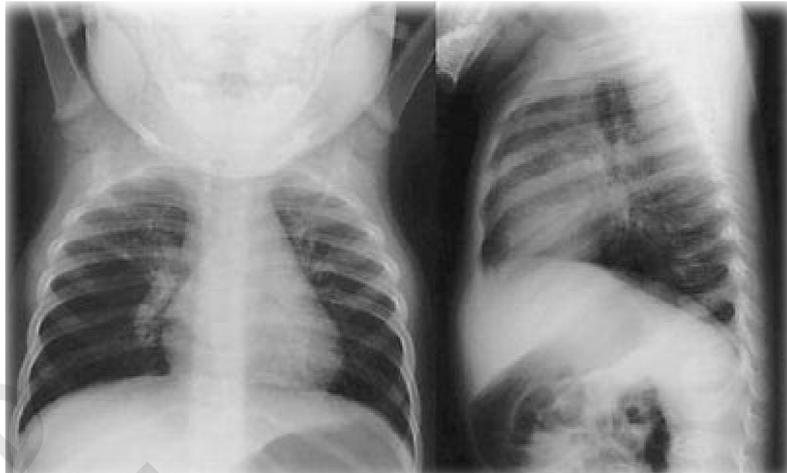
Chest Radiograph of a Six-Month-Old Infant with hMPV Bronchiolitis ⁽⁵²⁾
